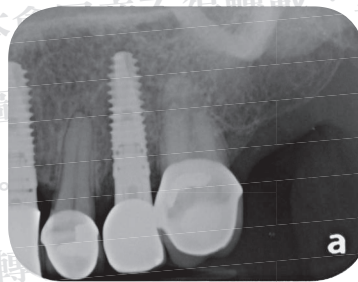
Periapical radiograph of tooth #25, which was replaced with an implant-supported prosthesis on June 11, 2014.
